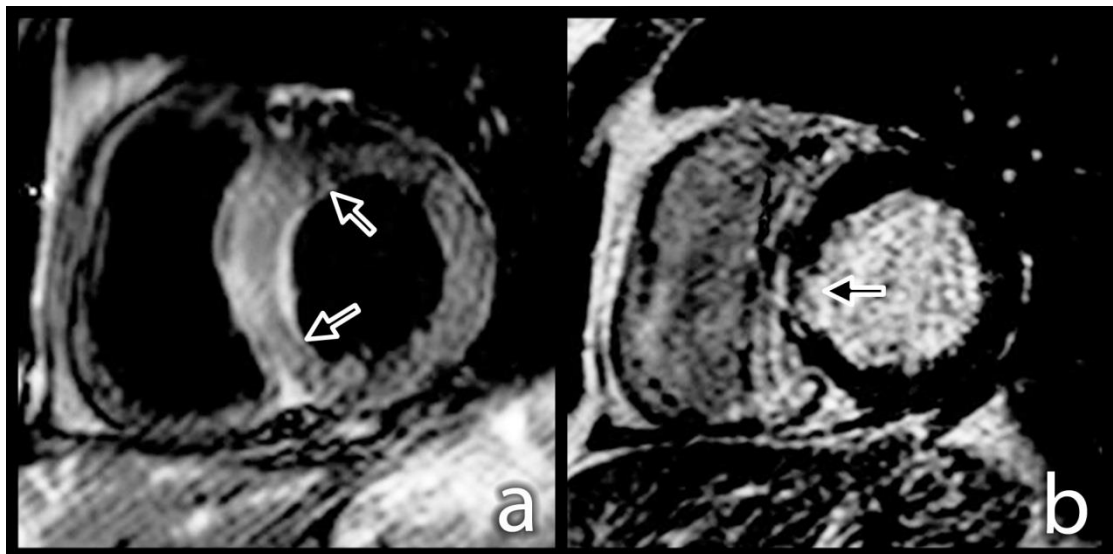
T2 and LGE imaging. Comparison of T2-weighted CMR (Panel a) and late gadolinium enhancement CMR (Panel b) in the same patient and slice location 2 days following reperfusion of AMI. Lateral extension of oedema (Panel a, arrowed) is more extensive than infarct (Panel b, arrowed).
